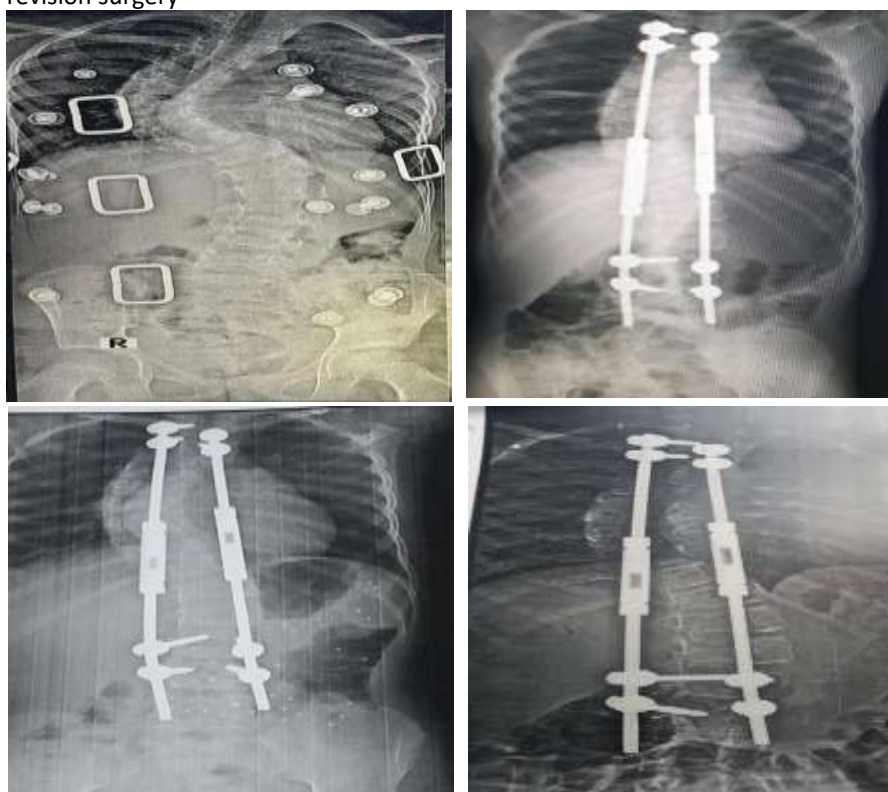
Serial X-ray Ap (A) preoperative (B) post-operative (C) after 1st tighten, (D) after 2nd tighten
